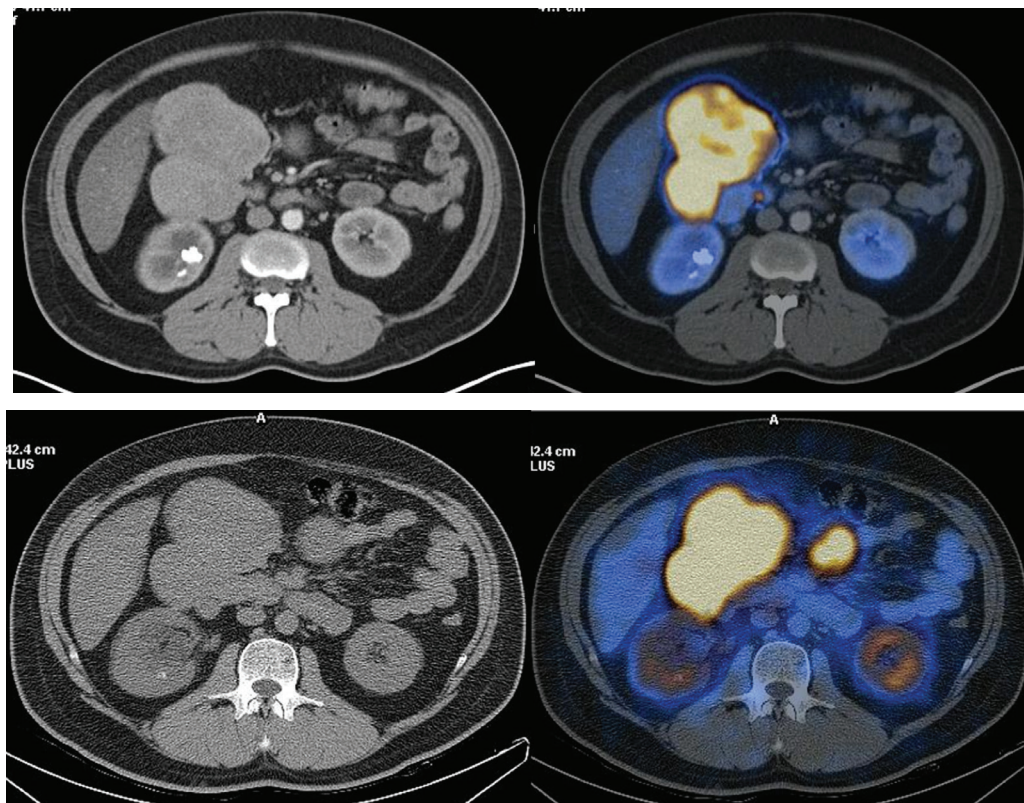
A: $[^{68}\text{Ga}]\text{Ga-DOTANOC}$ PET/CT demonstrate tracer avid lesion in retroperitoneal lymph nodes. B: $[^{99\text{m}}\text{Tc}]\text{Tc-HYNIC TATE}$ scan demonstrate tracer-avid lesion in retroperitoneal lymph nodes
